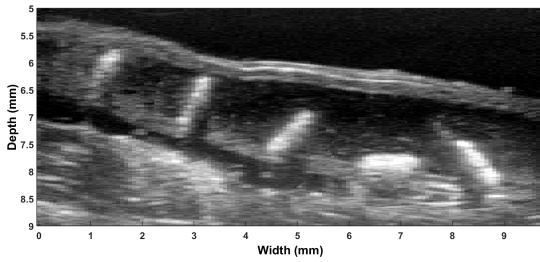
in situ* Dissected Tests: Ultrasound B-mode motion lapse of microrobot traveling within the sutured off colon filled with saline over a 3 second time period.
